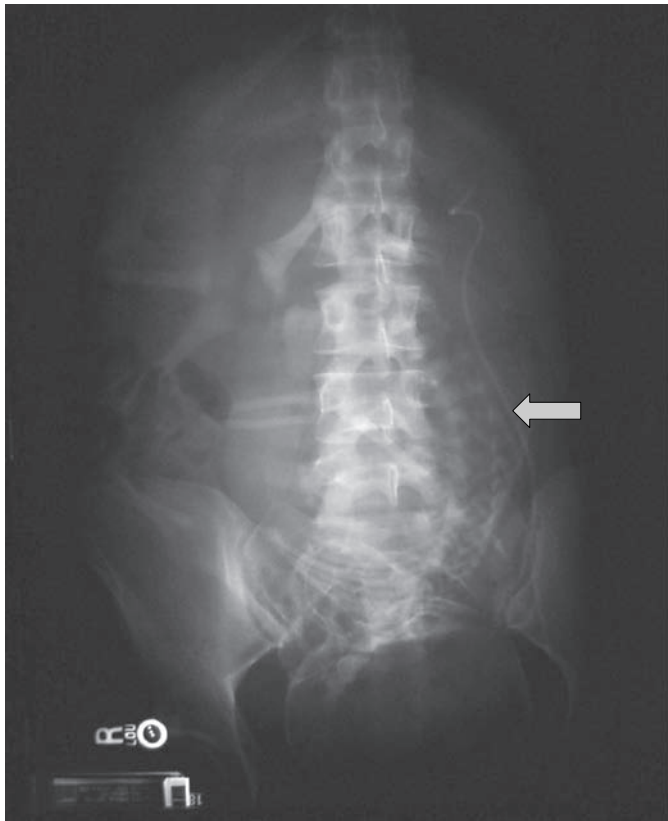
Plain x-ray of abdomen and pelvis in a woman at 36 weeks' gestation with severe flank pain associated with left ureteric obstruction and hydronephrosis. A left ureteric stent was placed under spinal anesthetic. The stent and a fetus with a head engaged in the pelvis are clearly seen. The arrow points to the left ureteric catheter. (See color plate section.)
